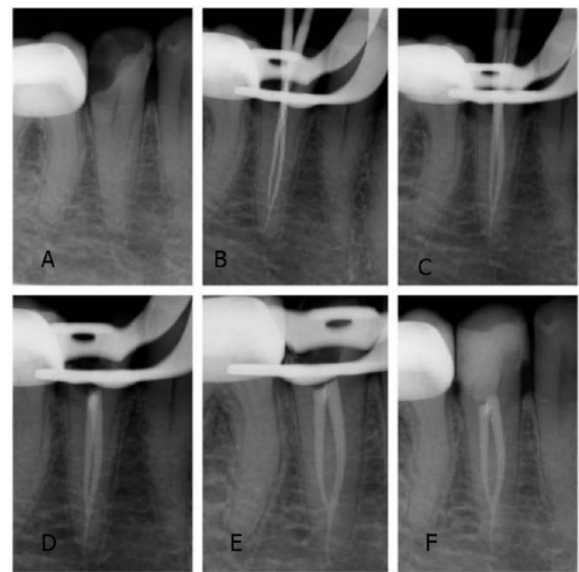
A. First diagnostic radiography; B. Working length determination; C. Verification of working length; D. Radiography after root canal obturation; E. Radiographic image from another view; F. Coronal filling.
